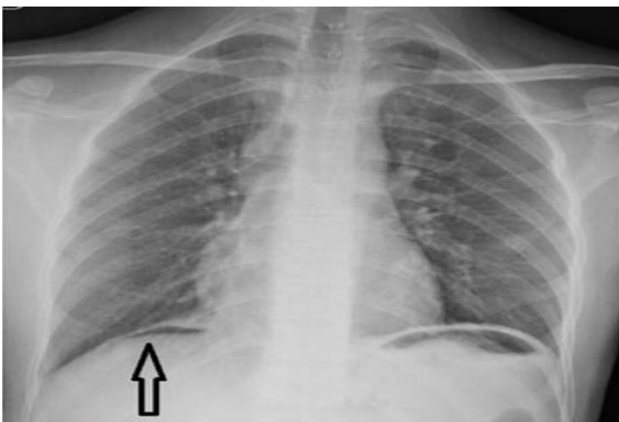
Chest X-ray following tracheostomy showing pneumoperitoneum (arrow).
